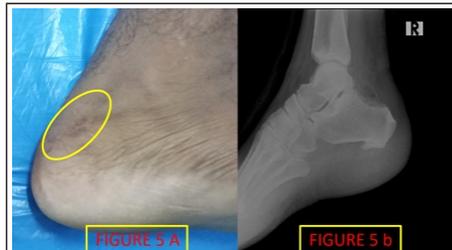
(a) Clinical photograph showing the healed surgical scar (as shown in yellow circle). (b) Radiographs at the end of 1-year post-surgical excision of Haglund's deformity.
